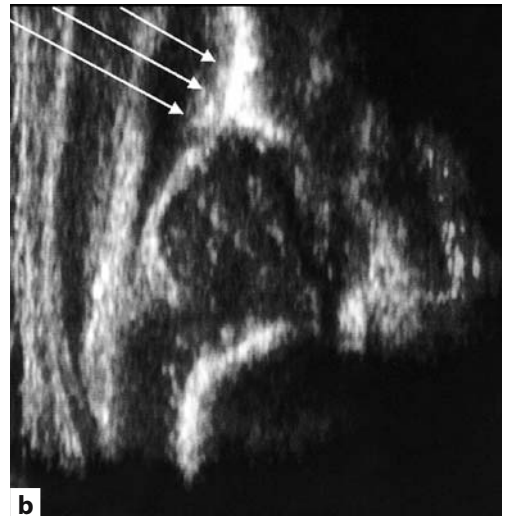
a The probe is tilted, with cranio-caudal direction of the ultrasound beam. b Image generated with tilting of the probe as described in a. The lower limb of os ilium is not visible. Compare with a correctly executed image, as seen in Fig. 12.1c
